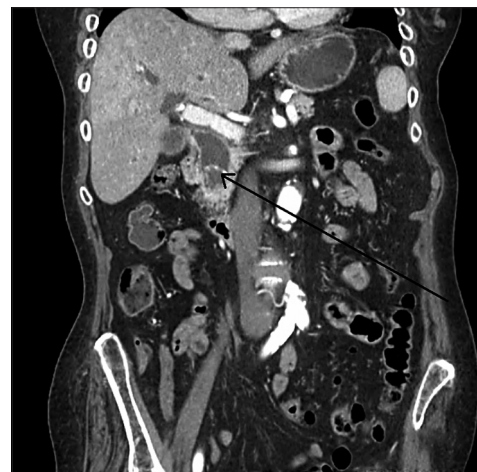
Coronal section from a Computed tomography scan of the abdomen showing the same stone in the common bile duct. Arrow pointing to the stone
